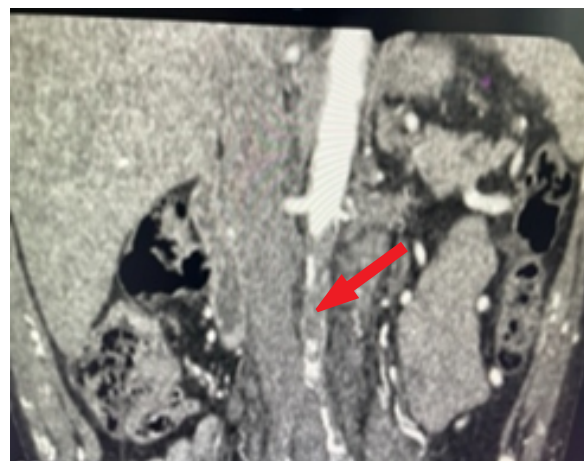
CT aortogram and renal angiogram showing the large thrombus in infrarenal aorta (Red arrow) extending to bilateral common iliac arteries.
